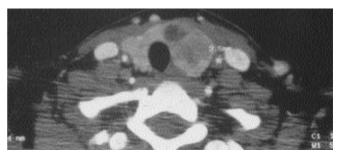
Contrast-enhanced CT scan. Presence of circumferential wall thickening of 3.5 mm of the left common carotid artery (indicated by a cross).
